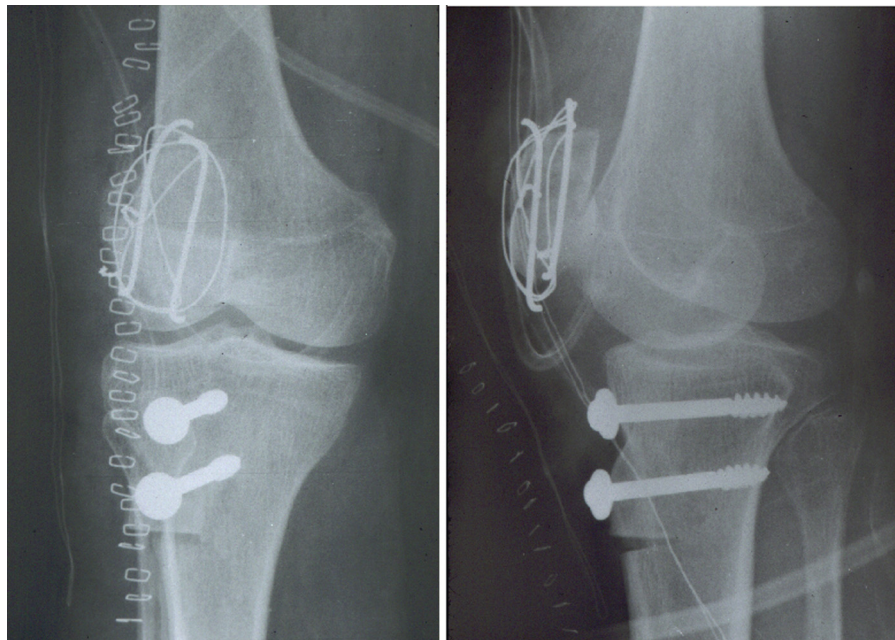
Postoperative x-ray images showing the fixation using two k-wires, tension band and two screws.
